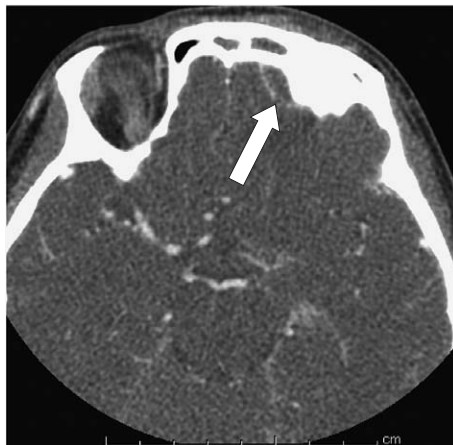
Enhanced CT obtained on March 31 showed a high-density area involving the bilateral ethmoid sinuses, maxillary sinuses, and ring enhancement in the left frontal tip (white arrow).
